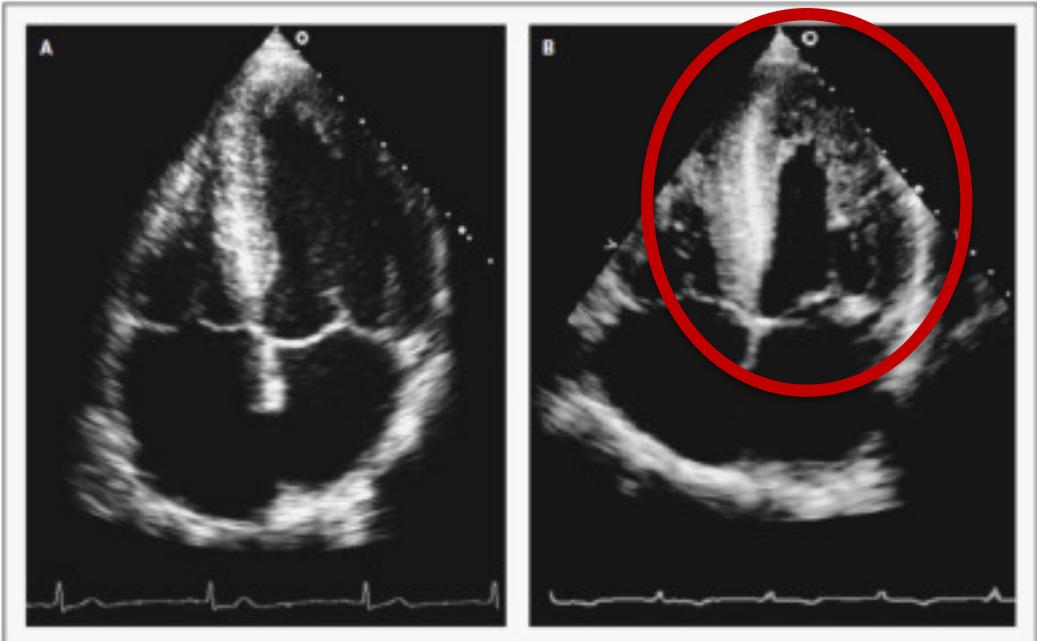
Echocardiographic Images in a Normal Person (Panel A) and the Patient with Diastolic Heart Failure (Panel B). The patient with diastolic heart failure has a thickened left ventricular wall and a normal left chamber volume.
